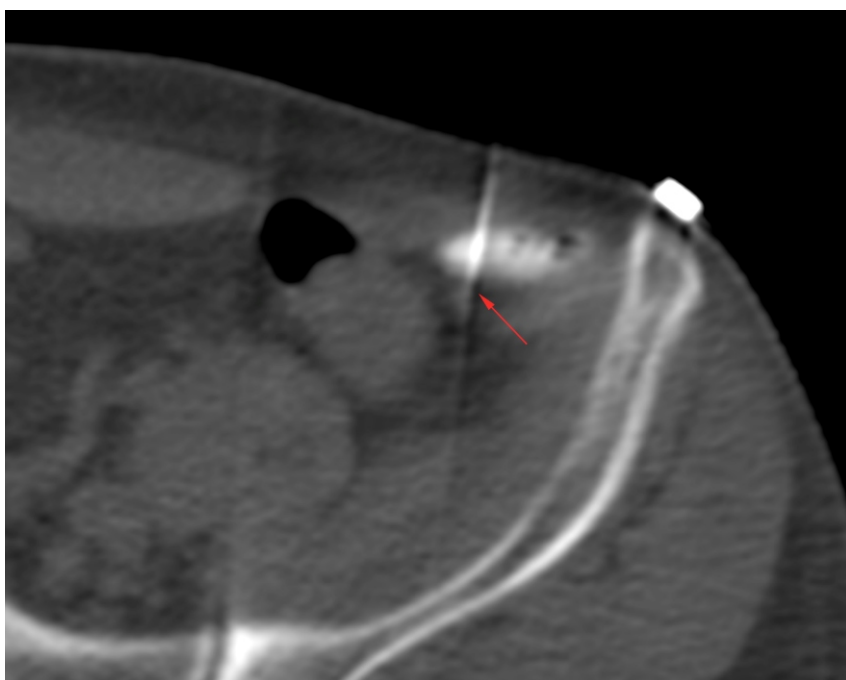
Nerve injection. CT guided injection of the nerve using a combination of long acting steroids and anesthetic.
